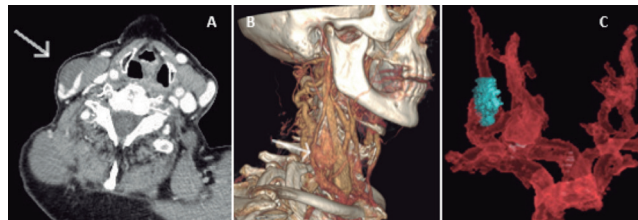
A-C: Computed Tomography Angiography of supra-aortic trunks showing saccular image in relation with EJV (Arrow). C. Volume Rendering.
